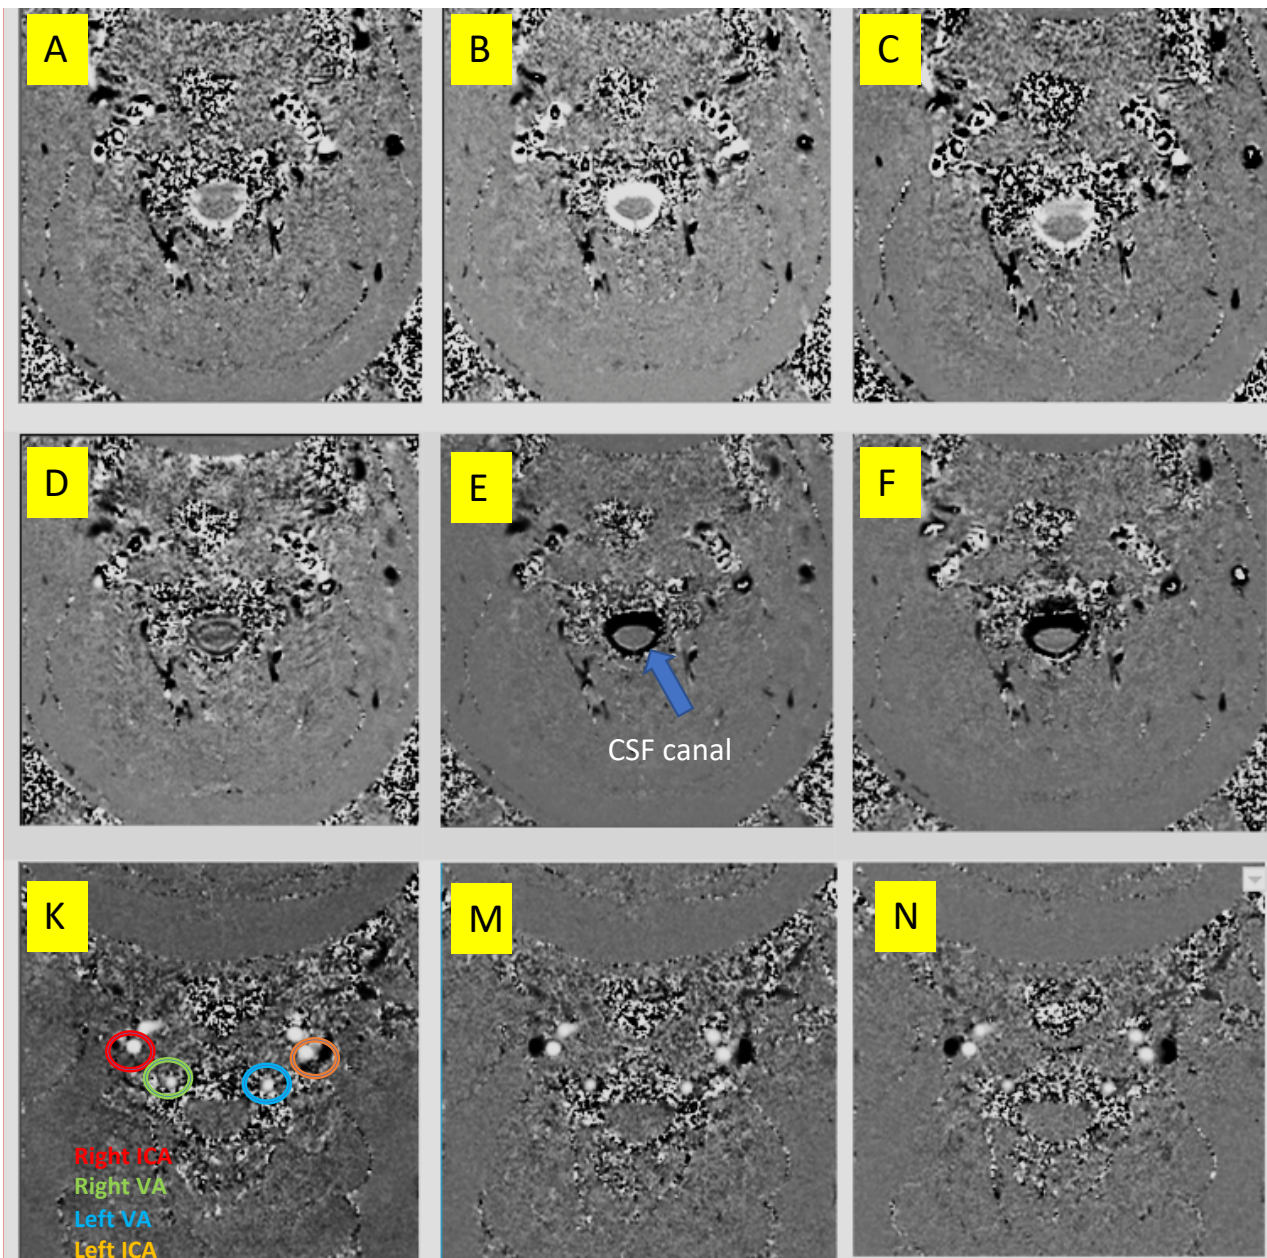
PC-MRI images at systolic, intermediate and diastolic phases of the cardiac cycle. The images from A to F are the selected phase images for CSF in the spinal canal. The images from K to N are selected phase images for arterial blood flow. The transverse plane was perpendicular to the arteries and was located at the C2-C3 cervical subarachnoid space. White pixels represent inflow and black pixels represent outflow. Gray pixels indicate a static region. To detect local phase error, a static region on phase data was selected that was close enough to vessel lumen while also far enough not to include vessel wall or air.
